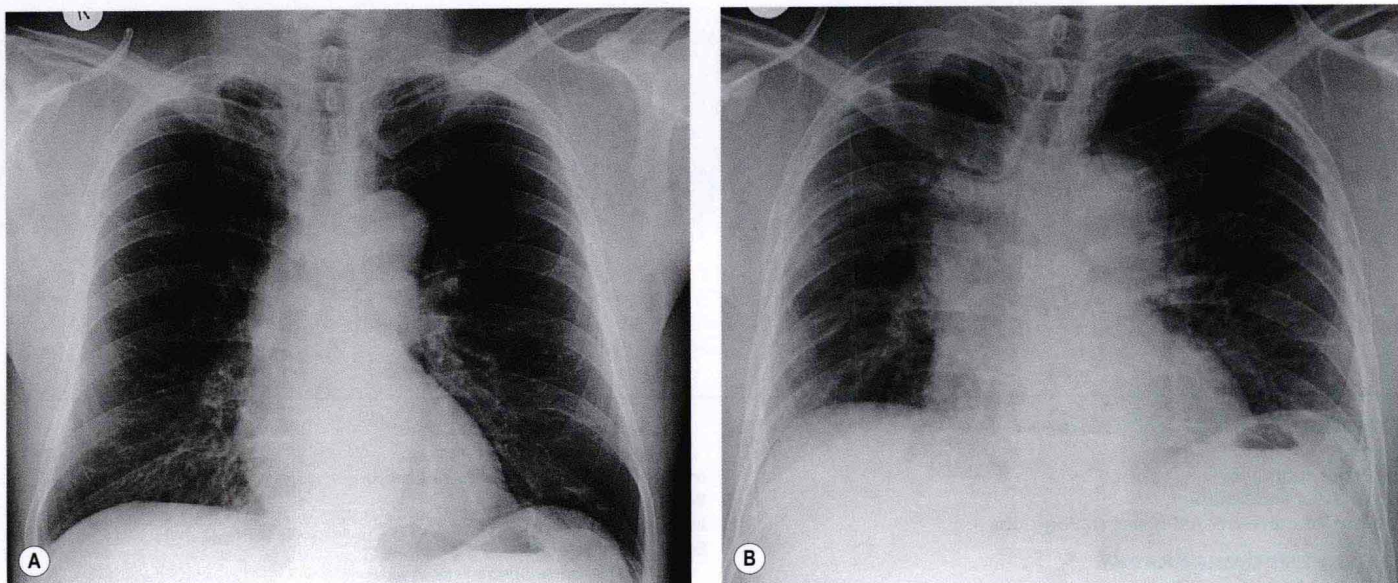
A, Normal chest radiograph of an individual breathing at full inspiration. B, By comparison, at full expiration the mediastinum appears abnormally widened and there is the appearance of a diffuse increase in lung density.
